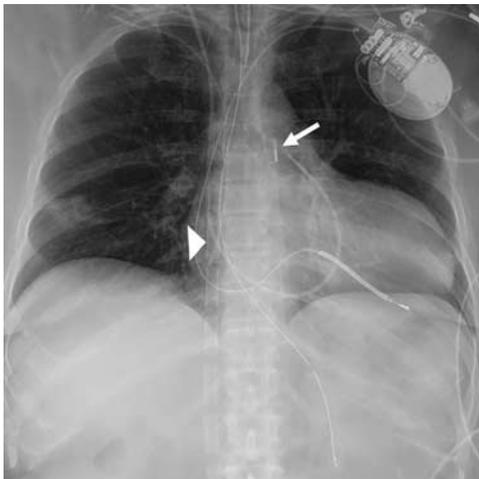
Veno-arterial (VA) ECMO: frontal radiograph in patient with VA-ECMO because of myocardial infarction. The venous cannula terminates in the RA (white arrowhead). The arterial line is in the right femoral artery, not depicted. IABP tip (white arrow) in expected location.
